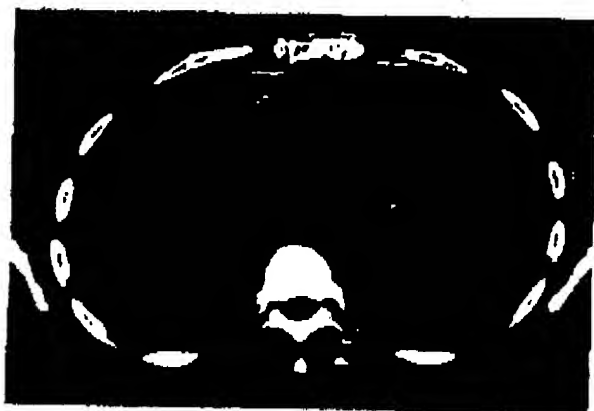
Axial CT scan through the mid-portion of the heart in a patient with recent cardiac surgery without the insertion of a PHB patch. The space between the retrosternal and cardiac surface shows no fat. This indicates postoperative adhesions in this area (arrows).
